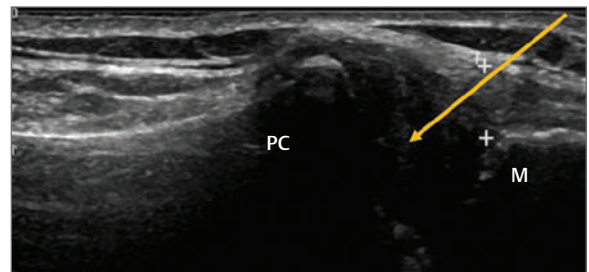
Ultrasound image of the sternoclavicular joint. The proximal end of the clavicle (PC) sits more anteriorly relative to the manubrium (M) (indicated by white crosses). The needle should be directed to the proximal face of the clavicle (straight arrow).
